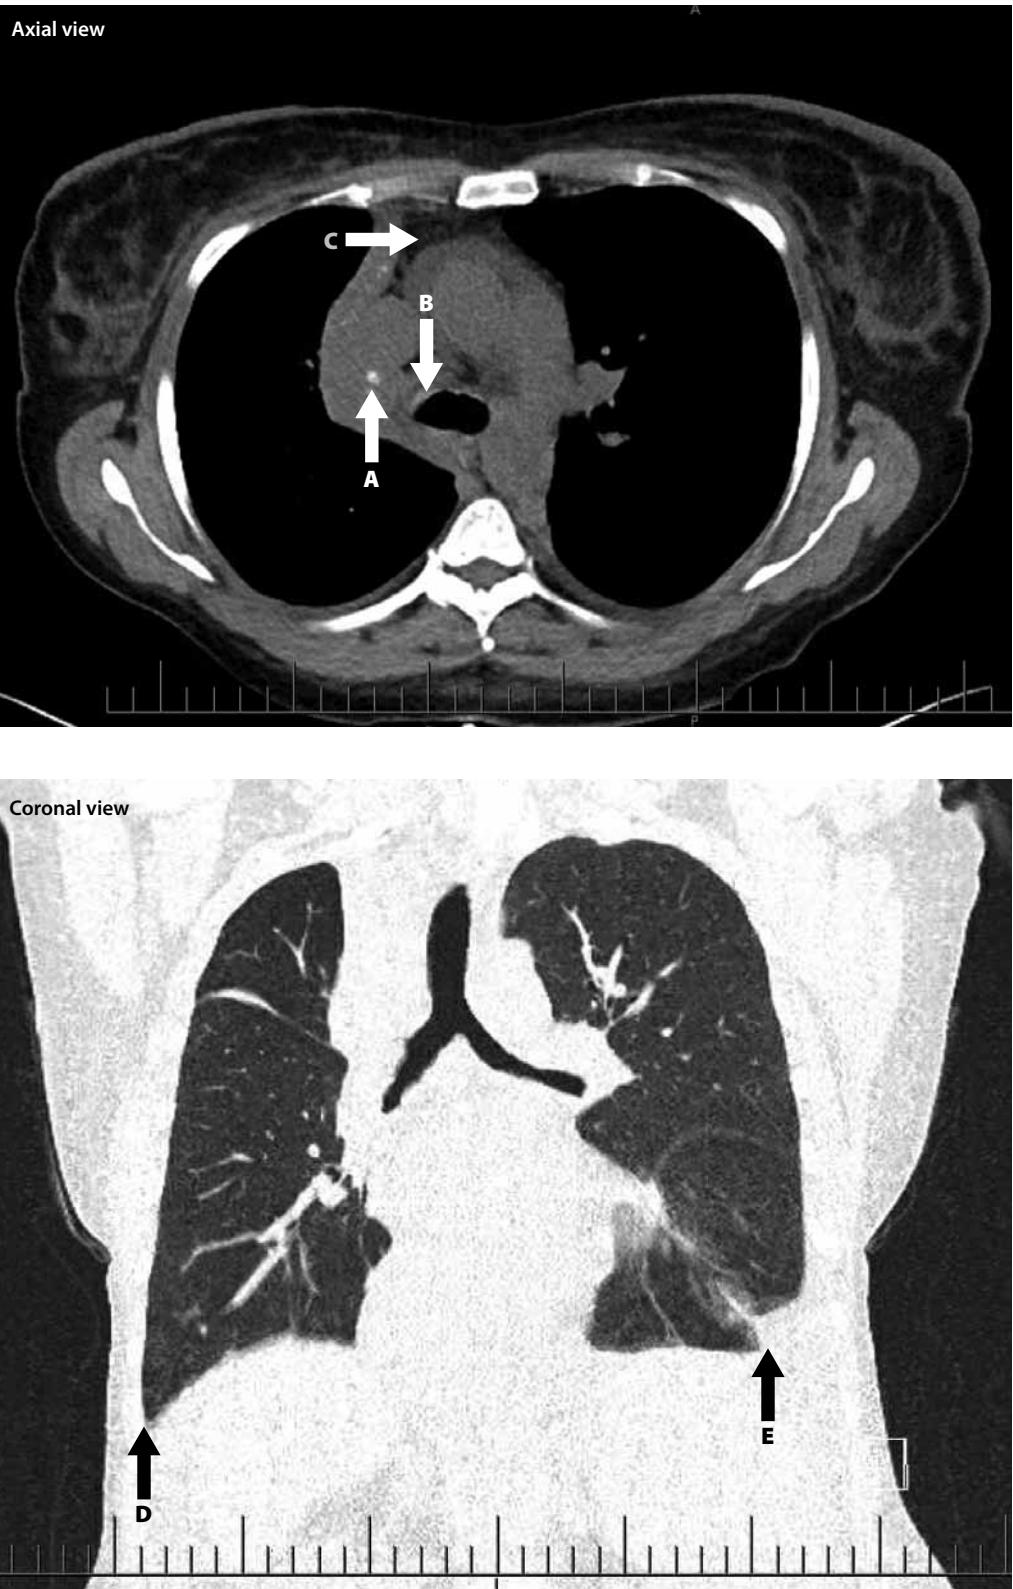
CT images obtained for reassessment of the patient reveal further collapse and consolidation of the right upper lobe and obstruction of the upper lobe bronchus. Regions of calcification (arrow A) can be seen within the area of collapse and consolidation, which may lie within the bronchus. Persistent enlargement of paratracheal lymph nodes (arrow B) can be seen. Since the initial CT images were obtained a pericardial effusion (arrow C) has become evident, the right-sided pleural effusion (arrow D) has decreased, and the left-sided pleural effusion has increased (arrow E).
